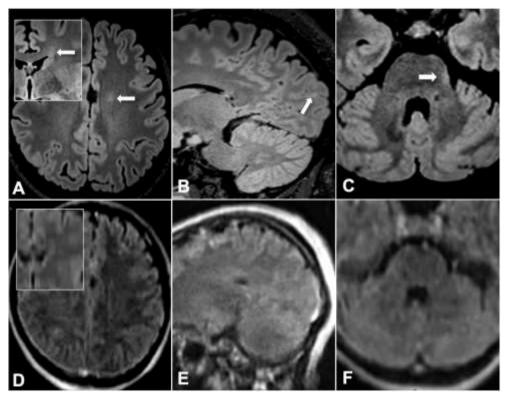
Examples of discordant findings. Axial T2-FLAIR (A, C, D, F) and sagittal T2-FLAIR images (B, E) on cMRI (top row, A-C) and pMRI (bottom row, D-F); insets in A and D are coronal reconstructions. Small left frontal periventricular (A, D), left occipital juxtacortical (B, E) and left pontine lesions (C, F) were only depicted on cMRI but not pMRI.
